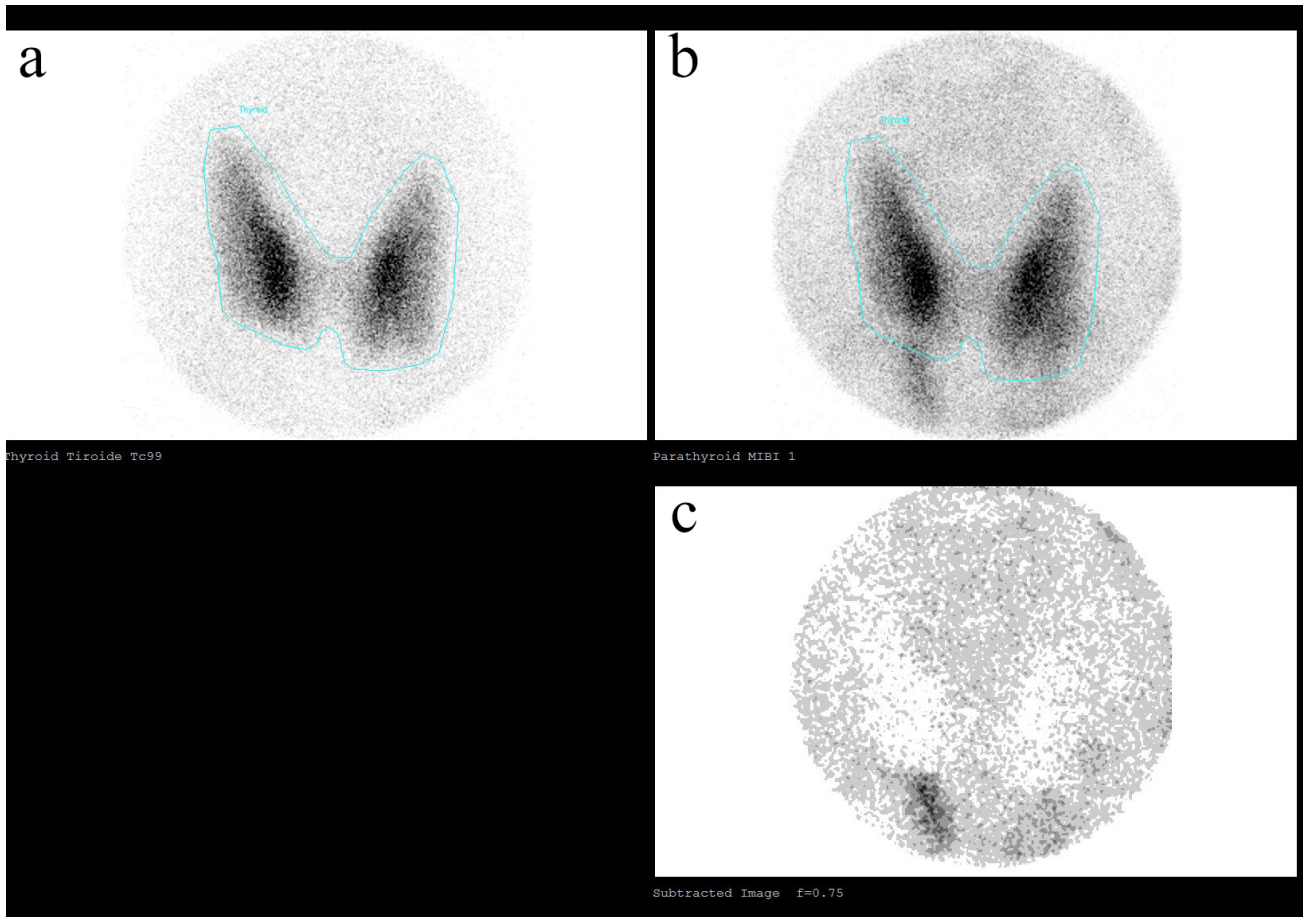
Case 6: sestamibi focal area SPECT/CT lesion located below the right thyroid lobe, which can be referred to as hyper-functioning parathyroid. (a) Thyroid parenchyma visualized following Tc-99m administration in SPECT. (b) Parathyroid and Thyroid parenchyma after MIBI administration. (c) Subtracted imaging (only parathyroid parenchyma).
